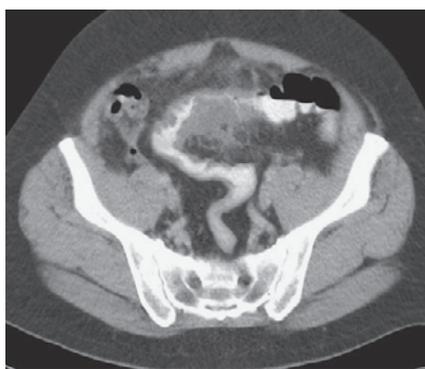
Active diverticulitis in the sigmoid on a computed tomography scan using contrast agent administered rectally. In the center of the image a highly inflammatory thickening of the sigmoid wall with inflammatory surrounding reaction and severely narrowed lumen only visible as a thin streak of contrast agent.
